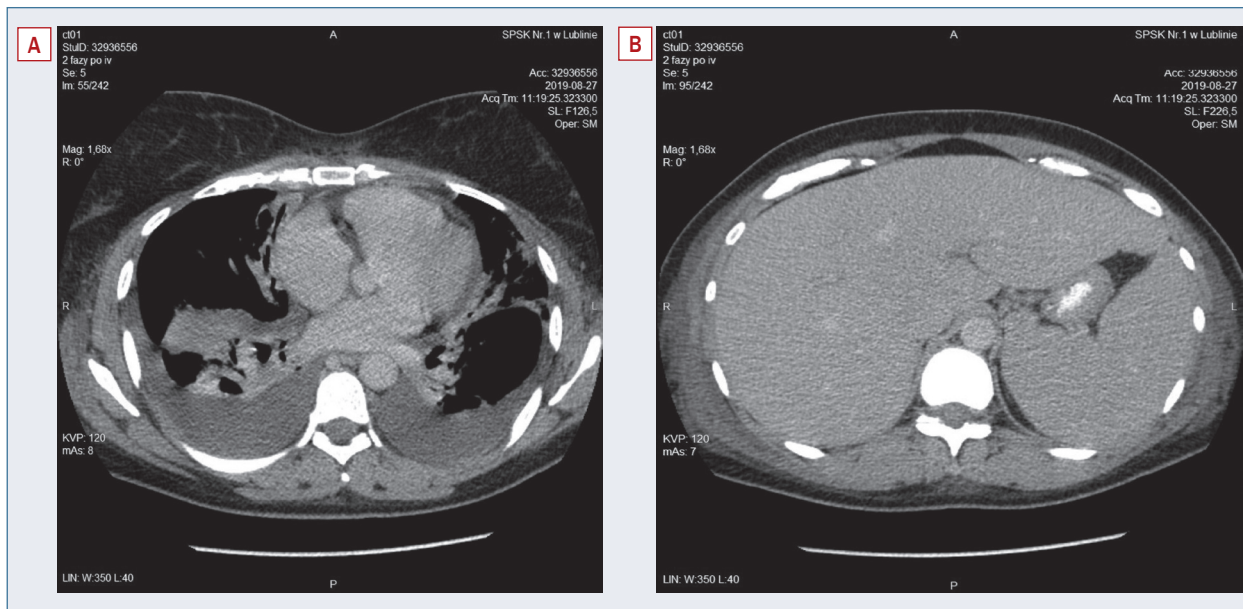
CT after admission, B. CT scan after admission
